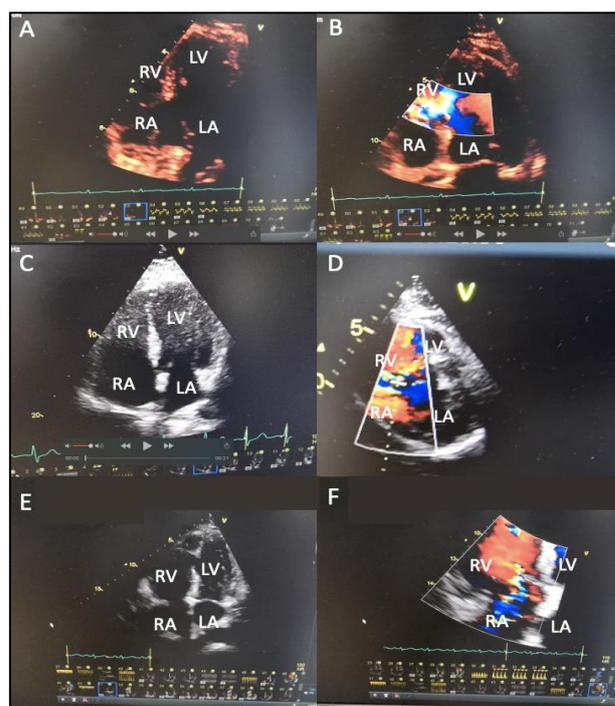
Echocardiogram shows a 66-year-old female with inferobasal akinesia with hypercontractility, LVEF 70%, cardiac output 8.27, (A) and a posterior interventricular septal rupture of 26 mm, maximum gradient 27 GLPS -10.4%. TAPSE 18, PCWP 28 and mild mitral regurgitation (B). A 72-year-old male with right ventricular systolic dysfunction, LVEF of 72% (C) and 7 mm ventricular septal defect, 18 mm aneurysm and PSAP 70 mmHg (D). A 57-year-old male systolic dysfunction of right ventricular, LVEF of 55% (E) and inferoseptal defect of 12 mm (F).
